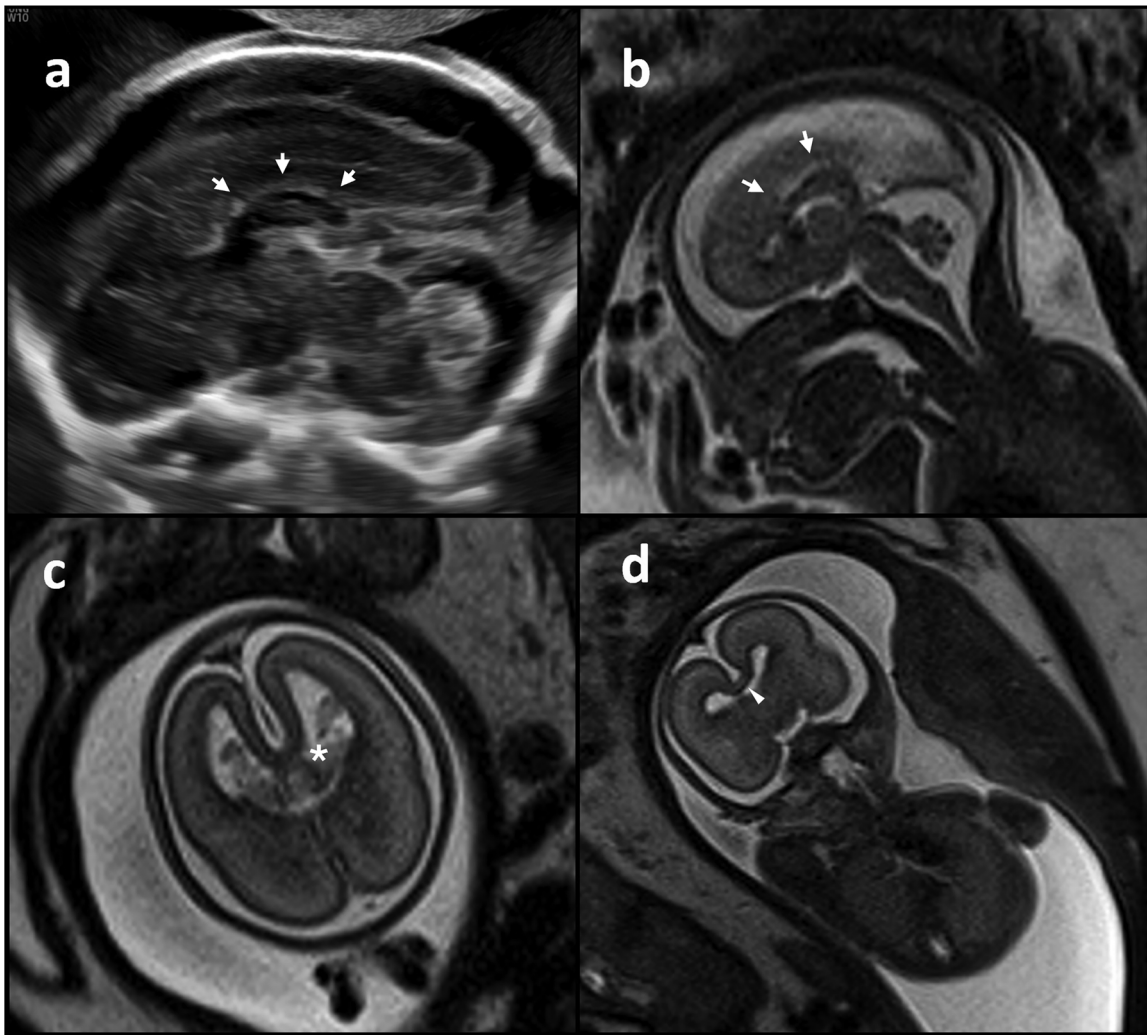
Fetal neuroimaging findings. Ultrasound (a) and magnetic resonance imaging (b) of the sagittal view showing the hypoplasia of the corpus callosum (white arrows). Magnetic resonance imaging of the transverse (c) and coronal (d) view showing partial separation of the frontal lobe (white asterisk), incomplete development of the corpus callosum and the presence of the sagittal scissure (white arrowhead), suggestive of lobar holoprosencephaly.
